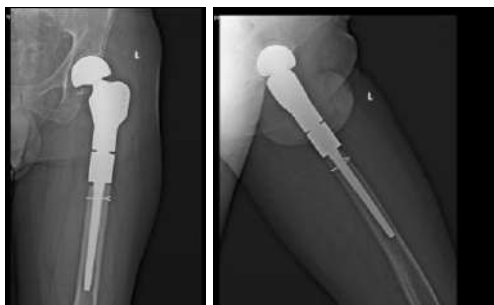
Five year follow-up x-ray images
